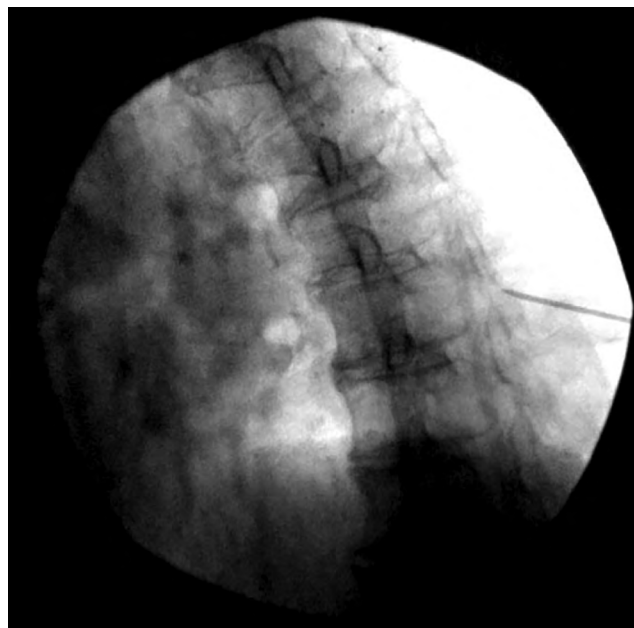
Lateral radiograph of the thoracic spine during interlaminar thoracic epidural injection. A Tuohy needle not advanced through the T7-T8 interlaminar space.
